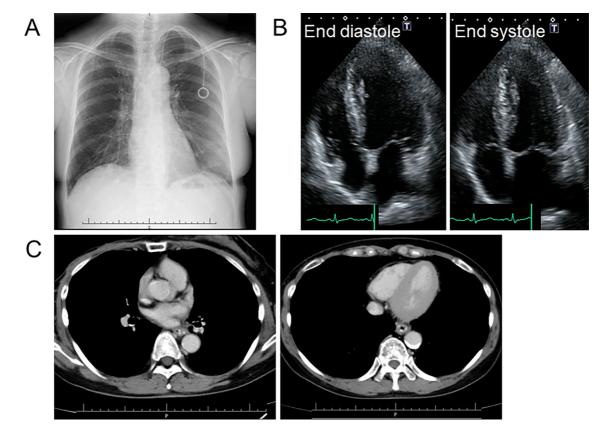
(A) Chest X-ray at eight months after discharge showing normal findings in the heart. (B) Apical four-chamber echocardiographic view at end diastole (left) and end systole (right) eight months after discharge showed a decrease in the left ventricular size (end-diastolic left ventricular diameter: 46 mm) and increase in the ejection fraction to 63%. (C) Contrast-enhanced CT findings eight months after discharge showing no intracardiac thrombus.
